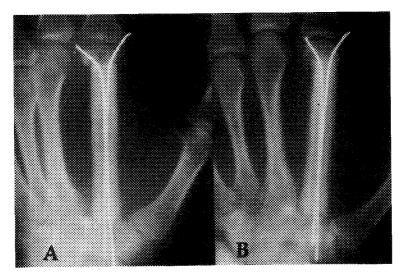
(A) Postoperative x-ray film. (B) Four years after surgery, showing the autograft consolidation.
